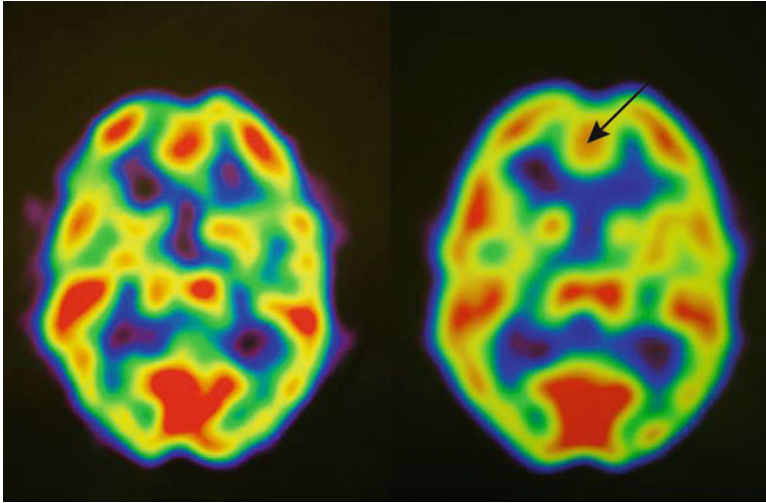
SPECT scan results comparing religious singing (a) and speaking in tongues (b) showing reduced frontal lobe activity during speaking in tongues
